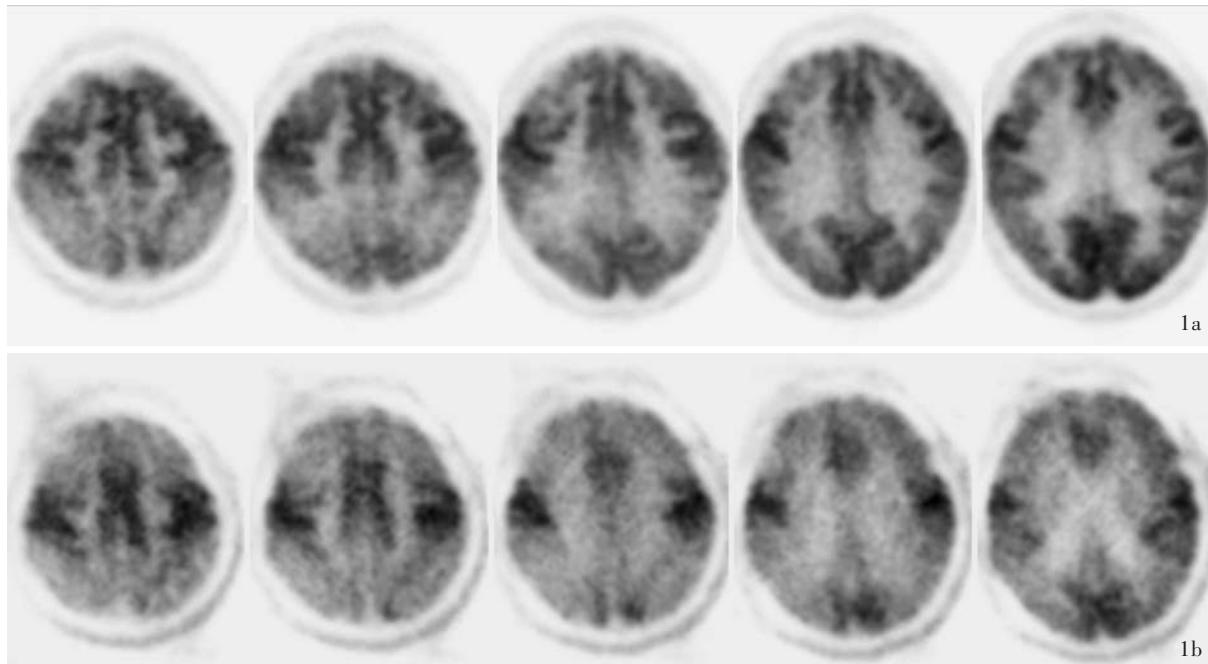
女性患者,57岁,临床诊断为阿尔茨海默病。 ^{18}F -FDG PET显像所见 1a 首次显像时MMSE评分21分,连续横断面扫描,双侧颞顶叶皮质对称性代谢降低,额叶背外侧部分皮质代谢降低 1b 30个月后再次显像时MMSE评分17分,连续横断面扫描,双侧颞顶叶皮质对称性代谢降低程度加重,且额叶皮质代谢降低程度和范围加重
